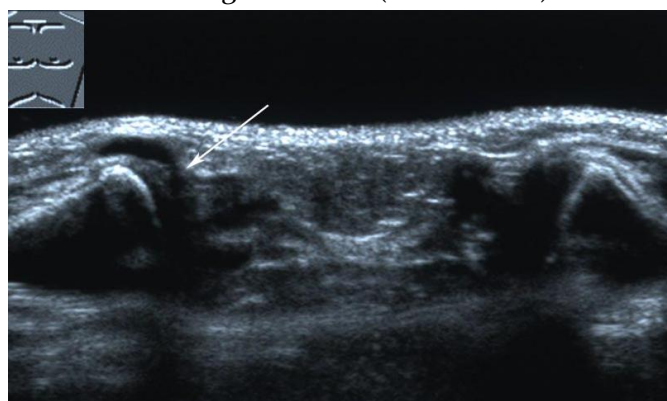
An axial ultrasound image of both sternoclavicular joints, using a broadband (frequency 8-14 MHz) linear array transducer and a standoff gel pad, shows an anechogenic cystic structure communicating via a stalk (white arrow) with the right SC joint.
